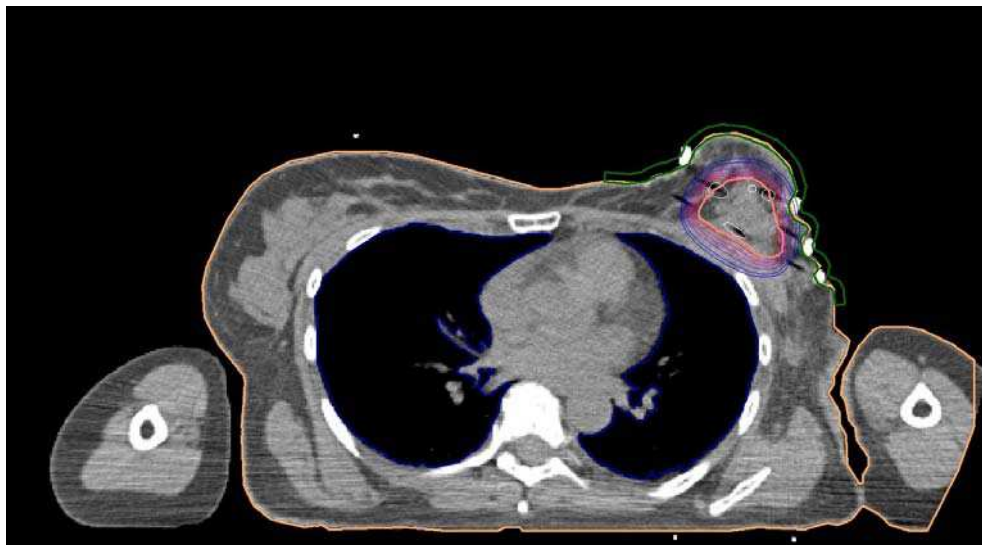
Breast cancer - Transverse CT scan with final plan - different isodoses allow to assess value of dose in tumor bed (target) lung, skin and other tissues.
